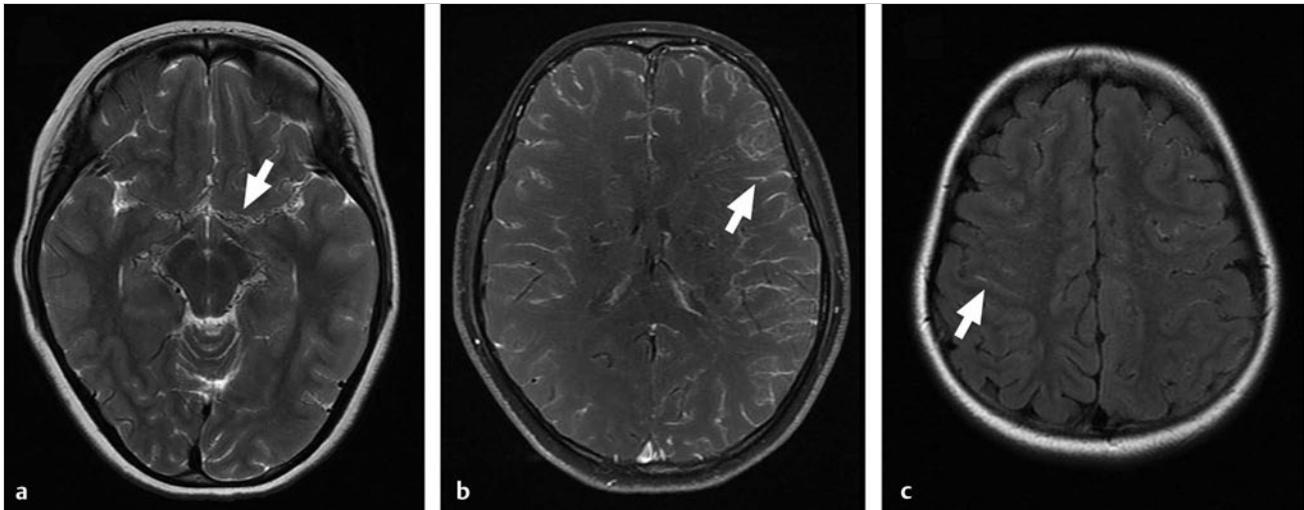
Magnetic resonance imaging of a 10-year-old girl who presented with multiple recurrent transient ischemic attacks causing weakness of the right arm and side of the face. She was neurologically intact at the time of her assessment. T2-weighted image demonstrating multiple small flow voids in the basal cisterns (*arrow*), representing moyamoya collateral vessels (a). T1-weighted gadolinium-enhanced image (b) and FLAIR (fluid-attenuated inversion recovery) image (c) demonstrating linear sulcal hyperdensities (*arrows*), referred to as the “ivy sign,” that are thought to represent slow flow through dilated cortical vessels.
